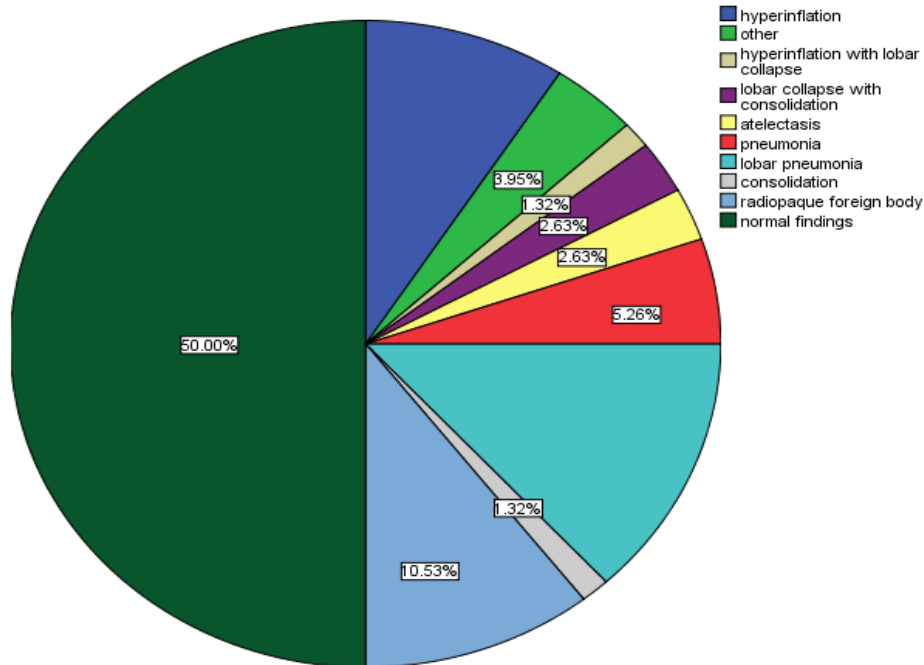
Chest x-ray Finding of Patients with Foreign Body Aspiration
